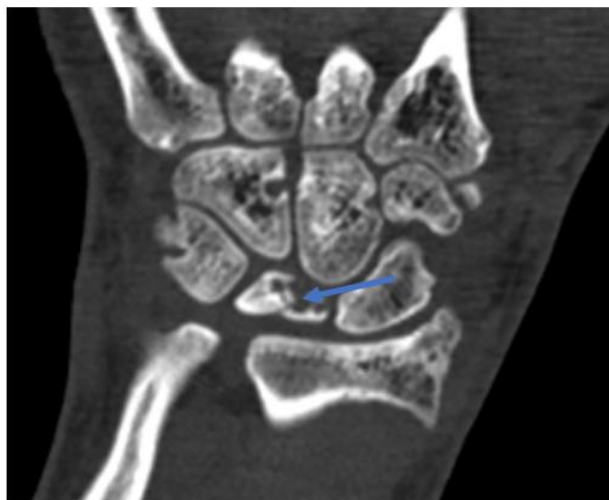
Coronal CT image of the wrist showing a dense and fragmented lunate (blue arrow).
